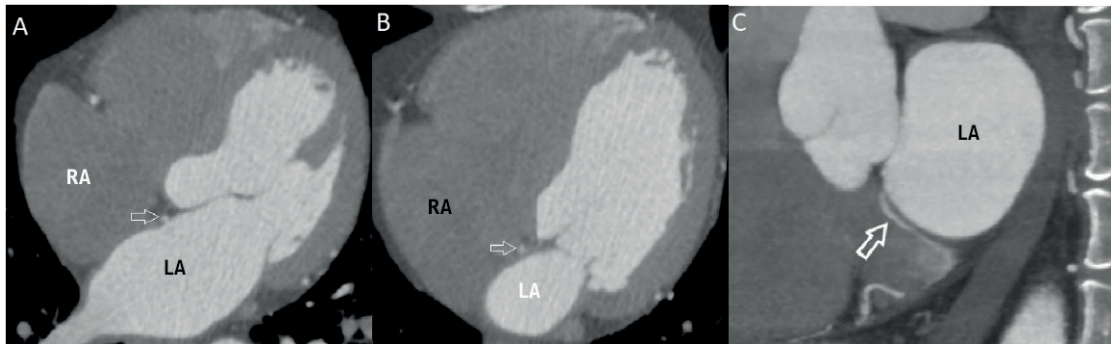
Coronary computed tomography angiography. Four chamber views (A, B) and sagittal view (C) showing a bridging vein with a 2.5 mm diameter (arrow) connecting the left atrium and coronary sinus. LA: left atrium; RA: right atrium.
